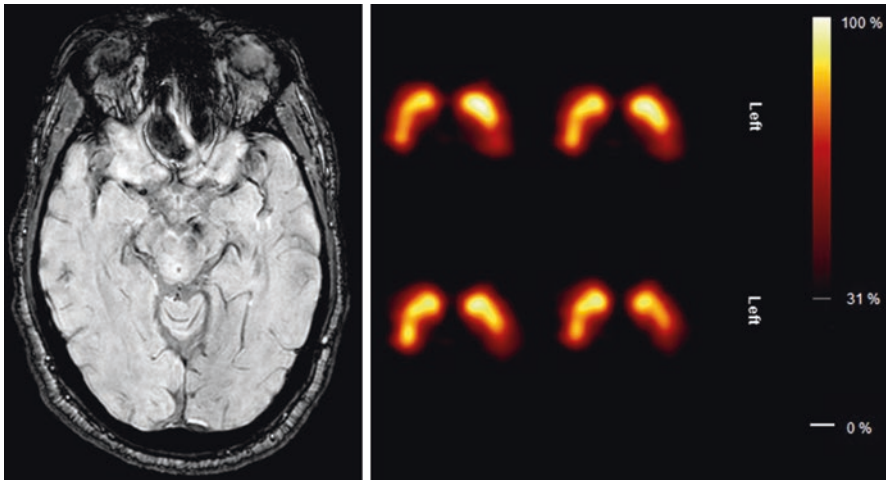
MRI (susceptibility-weighted imaging) and [^{123}I]FP-CIT SPECT scan of the brain in a patient with vascular parkinsonism. The small lesion (hematoma) at the level of the substantia nigra (left panel) induced the abnormal SPECT scan. Please note that the [^{123}I]FP-CIT binding is normal in the right striatum, and abnormal in the posterior part of the left putamen. This pattern is atypical for Parkinson's disease since there is no gradual posterior-to-anterior loss of binding (reprinted from Booij et al. *Imago* 2018)
